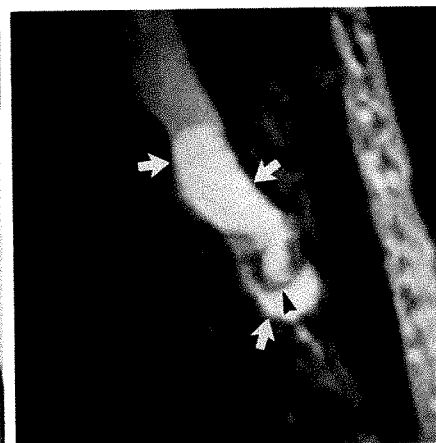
Ependymoma. Sagittal MR image, 500/30, shows neoplasm (arrowheads) filling most of sacral canal. Lesion has penetrated sacral cortex at S3–S5, resulting in presacral mass (arrow). Growth pattern of lesion is mainly longitudinal in sacral canal, suggesting neural origin.
